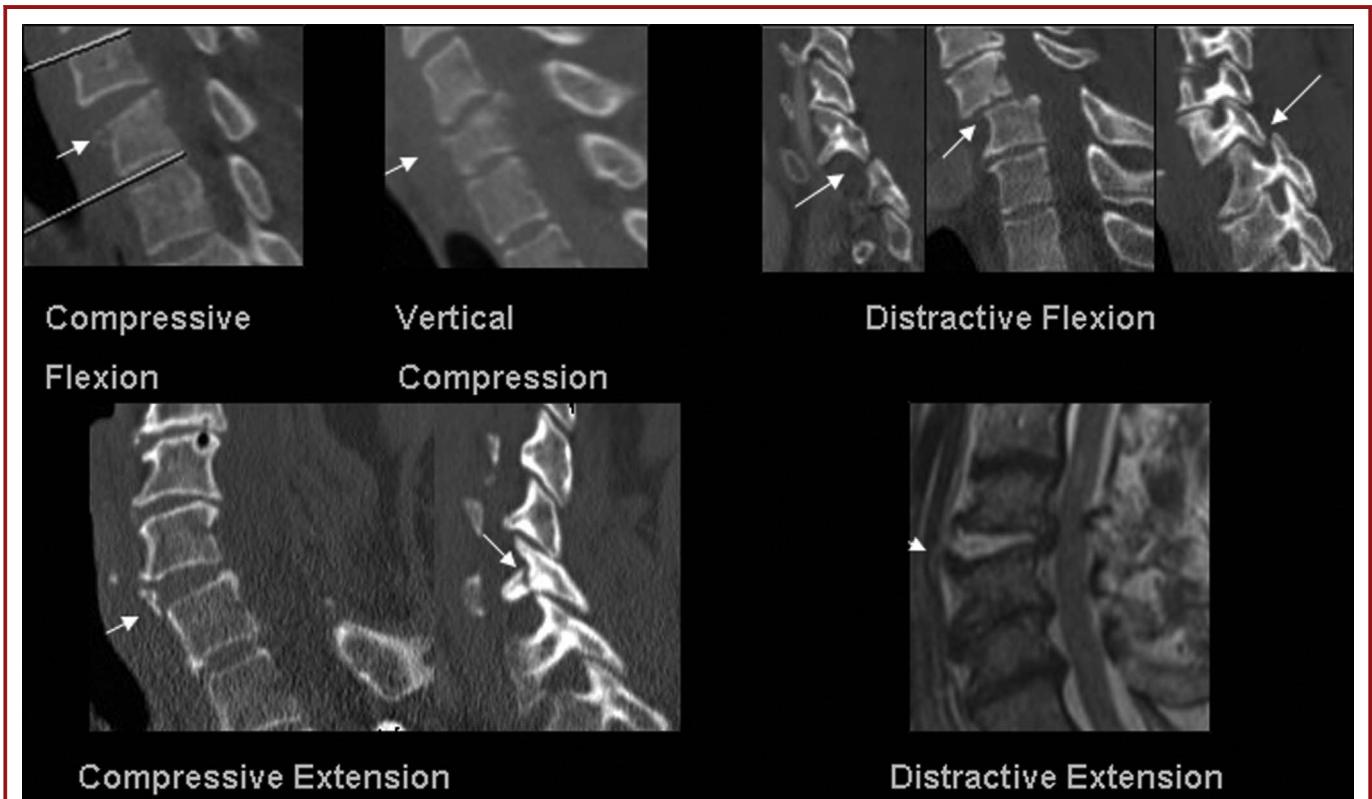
Reformatted computed tomography (Compressive Flexion, Vertical Compression, Distractive Flexion and Compressive Extension) and magnetic resonance (MR) views (Distractive Extension) of the Mechanistic Classification of Allen and associates. Each phylogeny can have several stages of injuries.
